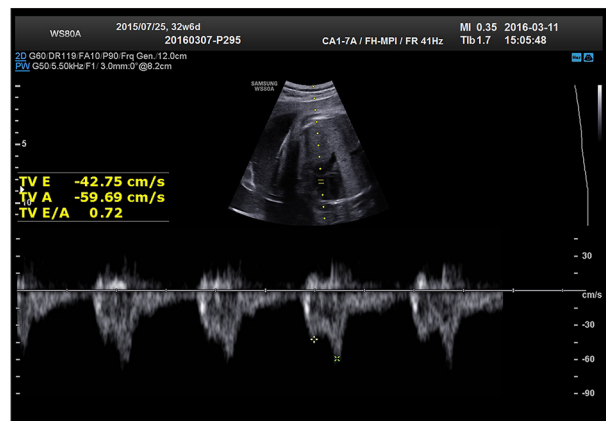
Ultrasound Doppler spectrum of fetal TV in the placenta previa group.
